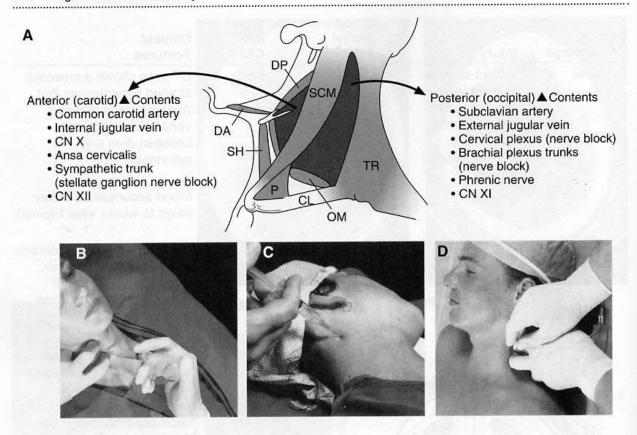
(A) Lateral aspect of the neck, showing the cervical triangles and their contents. Note that the common carotid artery, internal jugular vein, and CN X all lie within the carotid sheath. (B) Stellate ganglion, (C) cervical plexus, and (D) brachial plexus nerve blocks are shown. CL = clavicle; DA = digastric muscle (anterior belly); DP = digastric muscle (posterior belly); OM = omohyoid muscle (inferior belly); P = platysma; SCM = sternocleidomastoid muscle; SH = sternohyoid muscle; TR = trapezius muscle. (B, C, and D reprinted with permission from Scott DB: Techniques of Regional Anaesthesia. Stamford, CT, Appleton & Lange, 1989, pp 77, 93, 209).
